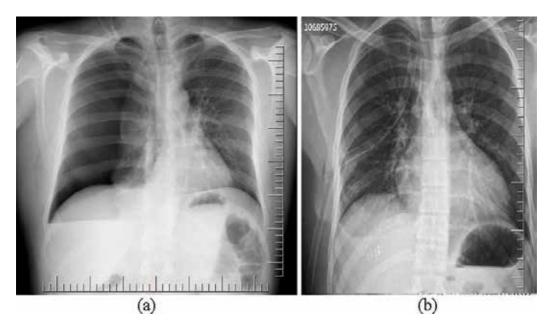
PA chest radiography of a case operated on with a right tube thoracostomy due to a developed traumatic right pneumothorax.
